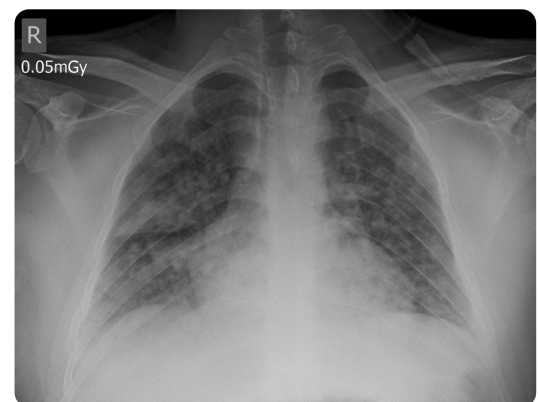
Initial chest X-ray. Alveolar occupation opacities, non-confluent, involving both lung fields.
